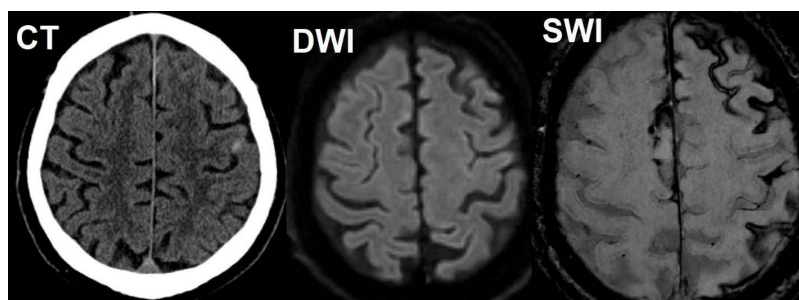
Superficial siderosis. A 60-y/o patient presents with progressive decline in memory and hearing for 6 years, episodic vertigo and disequilibrium for 2 years, and a sudden onset of “Novocain-like” paresthesia in the right side of the lips, cheek and right hand. CT (left) demonstrates hyperdensity in the left central sulcus, not seen on diffusion-weighted images (DWI). Susceptibility-weighted image (SWI) reveals multiple areas of superficial siderosis and hemosiderin deposits.
